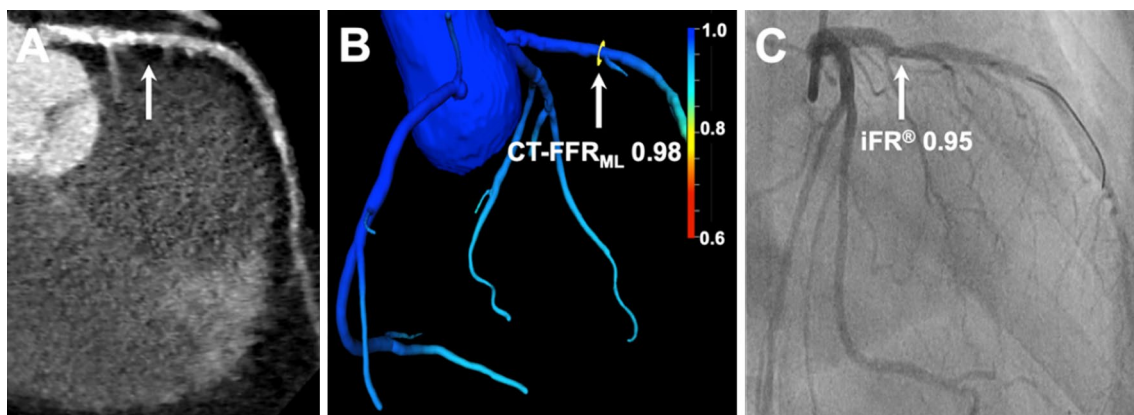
58-year-old woman with history of atypical chest pain, increased cardiovascular risk profile and pre-test probability for CAD of 20%. a cCTA demonstrates severe stenosis ($>70\%$) of the proximal left anterior descending coronary artery caused by calcified plaques (arrow). b $CT-FFR_{ML}$ derivation, displayed in a color-coded 3-dimensional mesh, resulted in a value of 0.98 (arrow). c Coronary catheter
